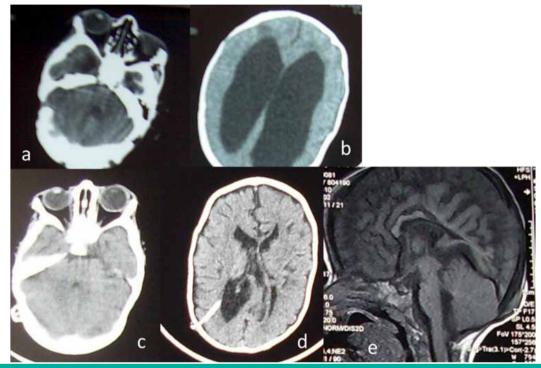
Brain CTs before (a and b) and after (c and d) shunt placement and midsagittal brain MRI after shunting (e) during the neonatal period showing no fourth ventricle dilatation (a, b and e), and dilated lateral ventricles before shunt surgery (b) diminished in size after shunting (d).
